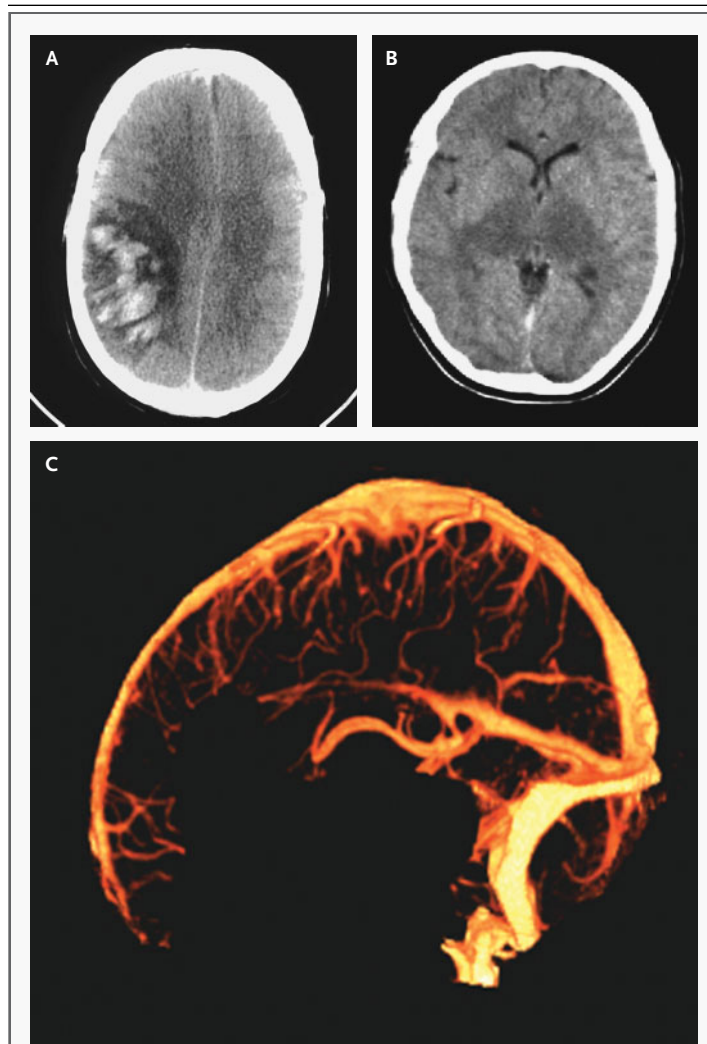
CT Imaging of Sinus Thrombosis.
